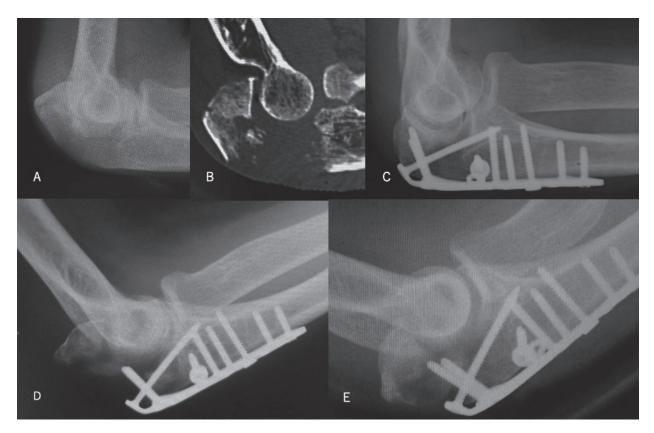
An 86-year-old elderly male with type IIB fracture. A and B, Preoperative X-ray and computed tomography. C, Immediately postoperative X-ray. D, One week postoperative X-ray. E, Final follow-up X-ray.
